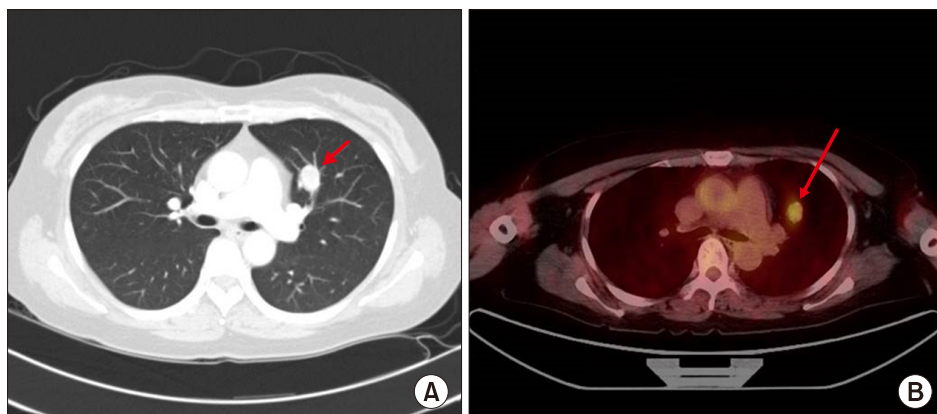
(A) Chest CT revealed a 1.9-cm, well-demarcated, oval-shaped, homogenous, well-enhanced soft tissue mass in the anterior segment of the left upper lobe of the lung (arrow). (B) On 18F-fluorodeoxyglucose positron emission tomography-CT, the mass showed hypermetabolic activity with a maximum standardized uptake value of 2.48 (arrow). There were no other areas of abnormal hypermetabolic activity. CT, computed tomography.
